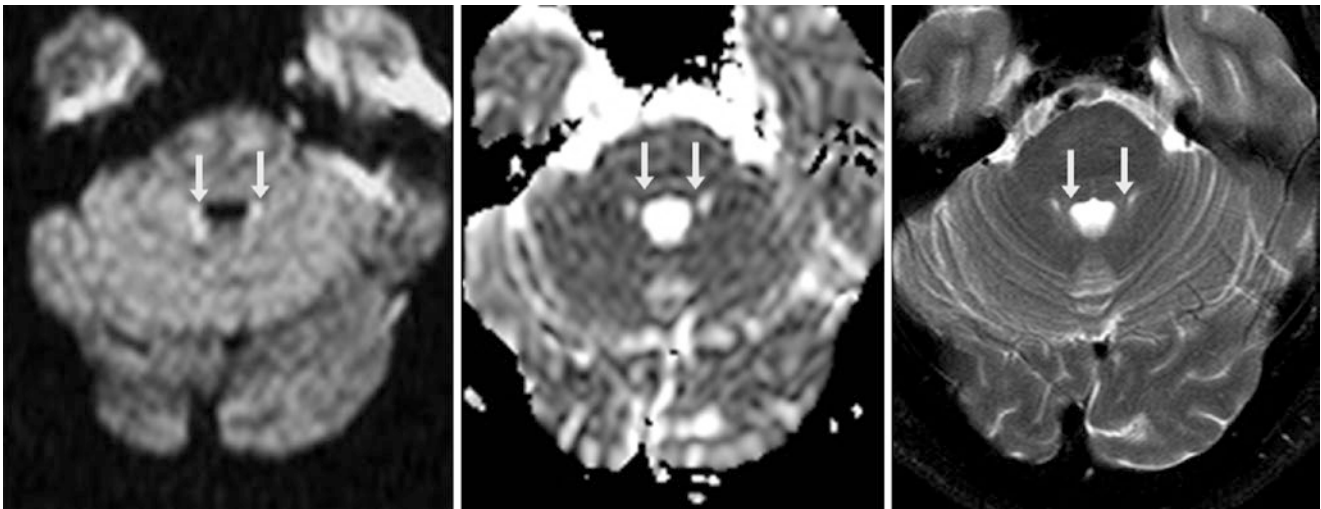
A 1.5 T MRI in a 49-year-old contains hyperintensity (*arrows*) within the superior cerebellar peduncle (SCP) bilaterally on DWI (*left*), but without corresponding bright signal (*i.e.*, edema) on the ADC map (*middle*). There is normal bright signal within that location
